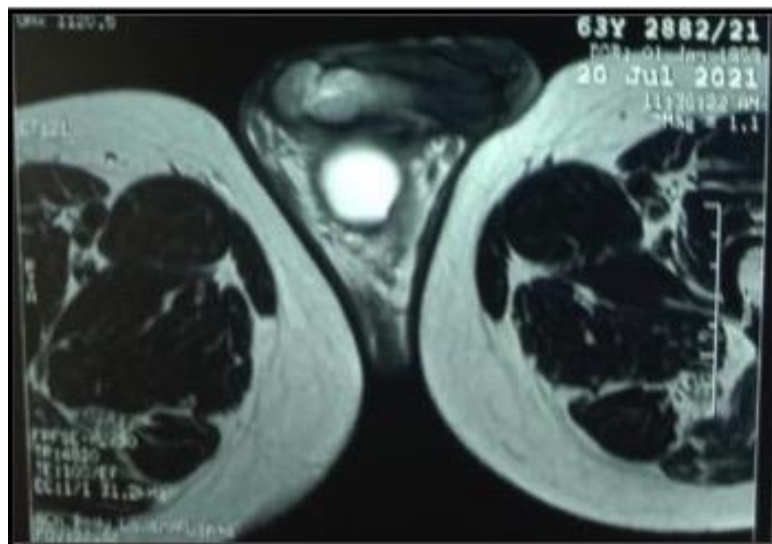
MRI image showing the cavernous lesion and cystic mass located between the penis and the perineum
